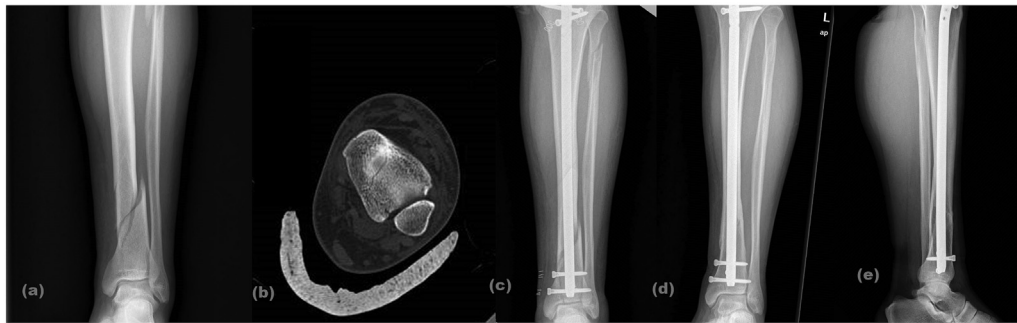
A 30-year-old male AO-OTA 43 C1 (a) preoperative X-ray, (b) preoperative computed tomography, (c) early postoperative X-ray, (d, e) postoperative X-ray at 19th month.
